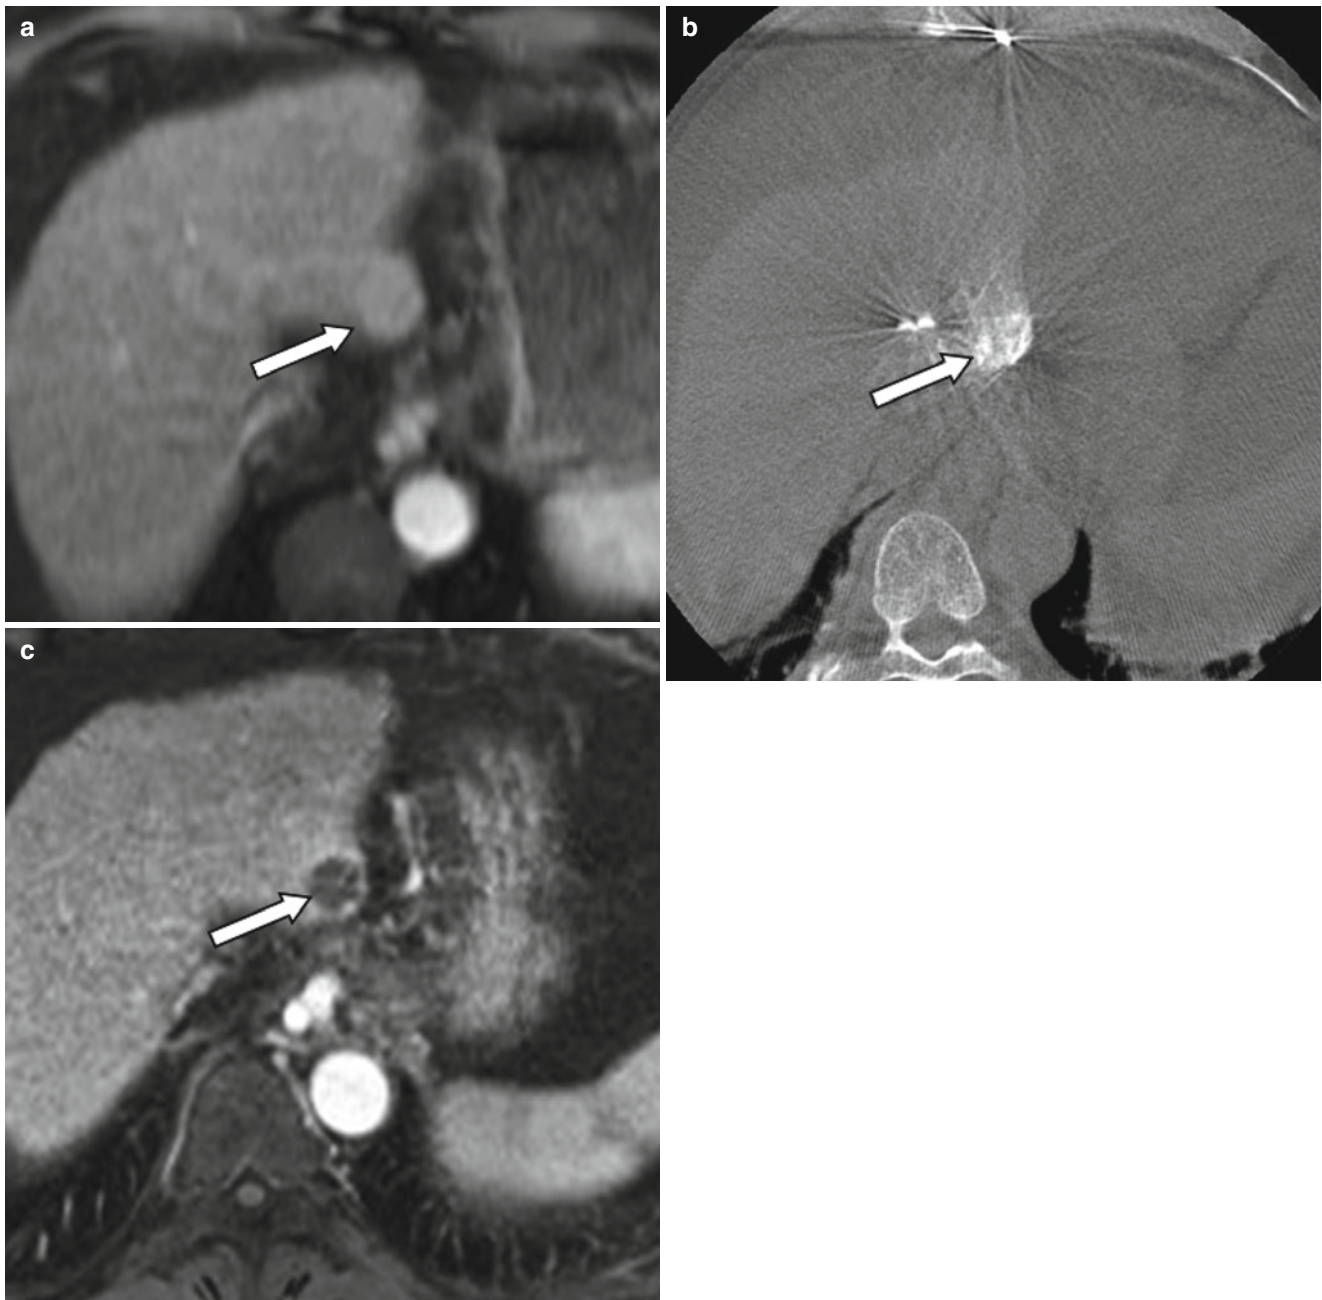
A 64-year-old male with unresectable HCC. The segment II lesion (*arrow*) demonstrates hyperenhancement on the contrast-enhanced gradient echo MRI images before treatment (a). Immediately after administration of radioembolization particles, DynaCT shows distribution of therapy throughout the lesion (b). Follow-up MRI demonstrates loss of enhancement compatible with a complete response to therapy (c)
